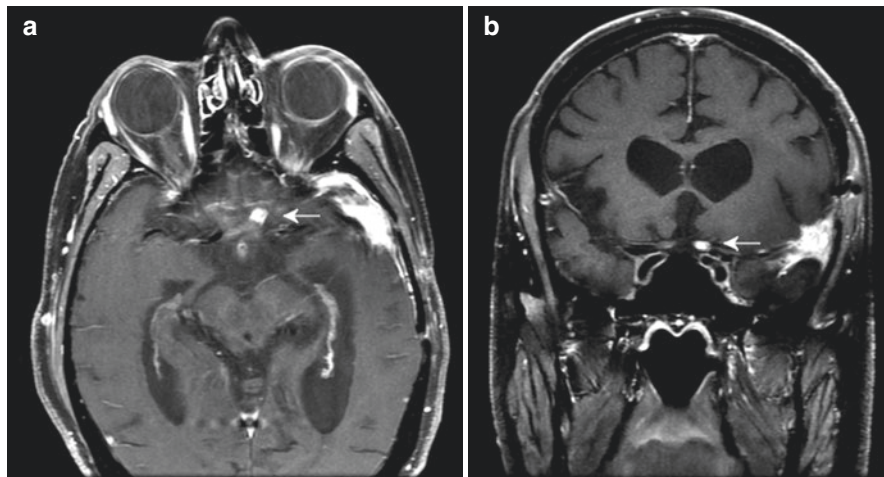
Axial (a) and coronal (b) T1-weighted postcontrast MRI demonstrates a discrete region of left prechiasmatic optic nerve enhancement (arrows). (© AD Henderson 2021. All Rights Reserved)
